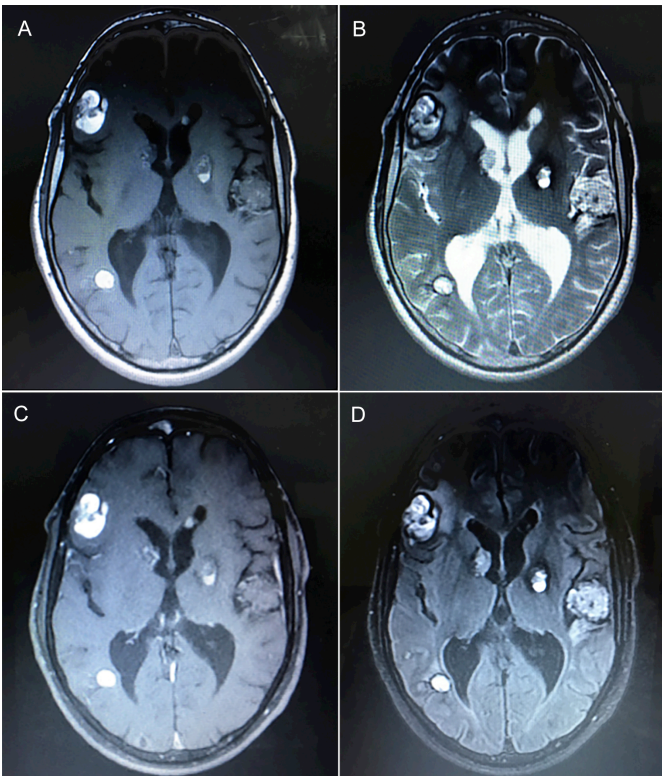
A and B (upper) and C and D (lower): Axial T1 and T2 MR Images (upper) and Gadolinium-enhanced and Fluid-attenuated inversion recovery (FLAIR) (lower) MR Images showing multiple characteristic 'popcorn-like' lesions called cerebral cavernous malformations.
